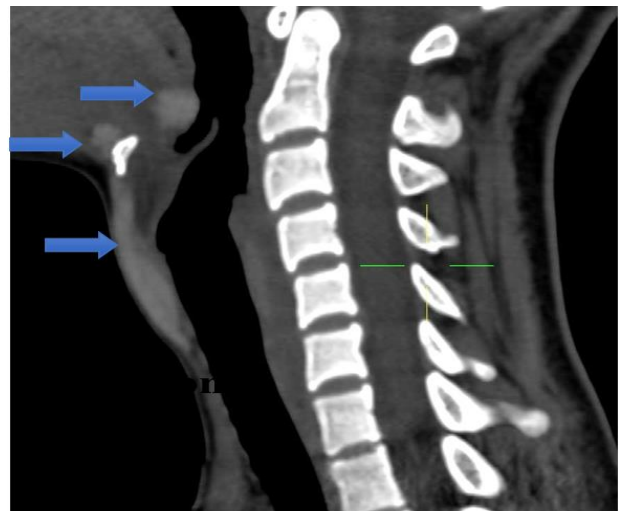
CT sagittal section of triple ectopic thyroid at three different regions.
